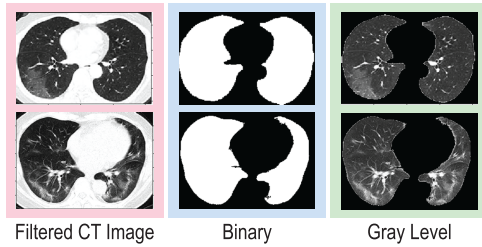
Lung extraction from filtered CT images. The filtered CT lung image is seen in the left, the binary lung extraction from the filtered CT lung image is in the middle and the gray level lung extraction of the filtered CT lung image is on the right.
